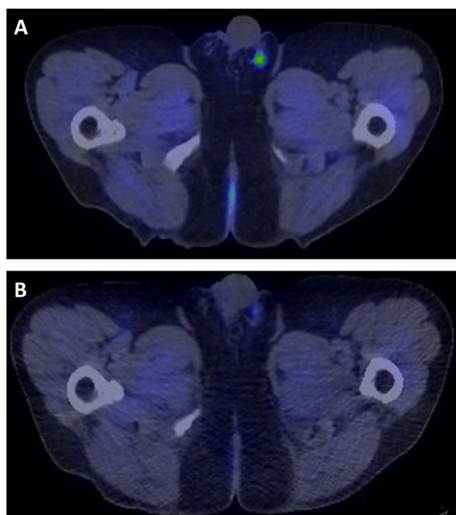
A: September 2018 ^{11}C -Choline PET/CT showing focal uptake in the left scrotum (Max SUV 4.5).
